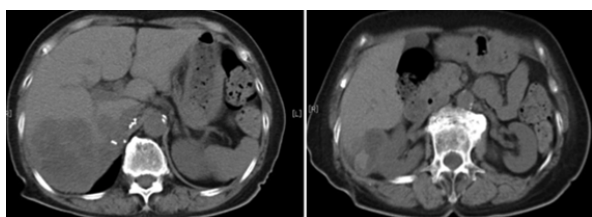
Computed tomography 1 year after surgery.
